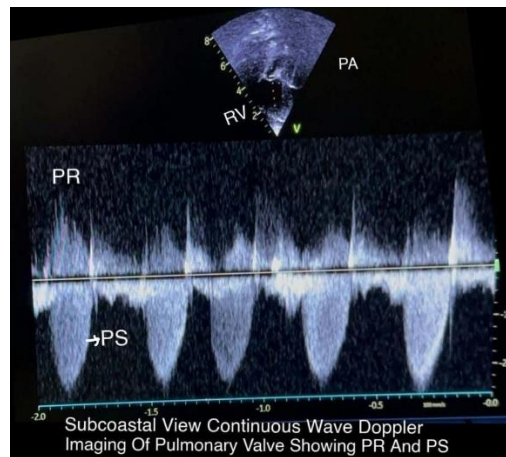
shows Subcoastal view continuous wave doppler imaging of pulmonary valve showing PR and PS
